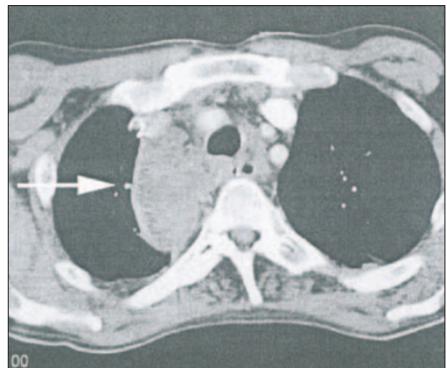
CT scan thorax shows persistent right mediastinal collection
